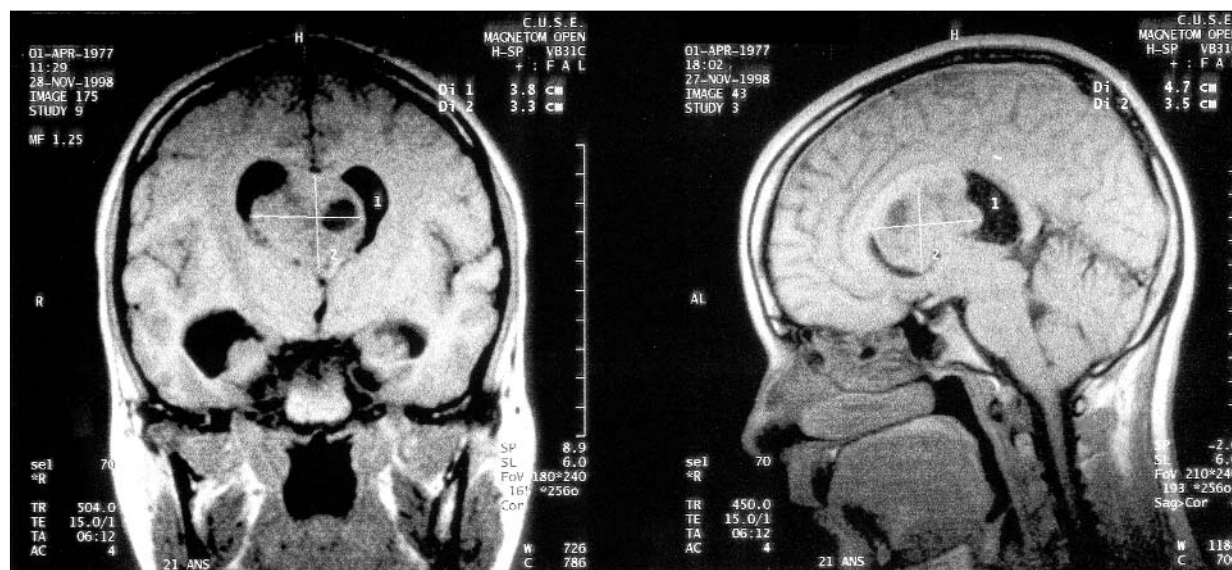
MRI (T1) image without gadolinium. Note the large intraventricular lesion, cystic areas and obstructed foramina of Monro.
